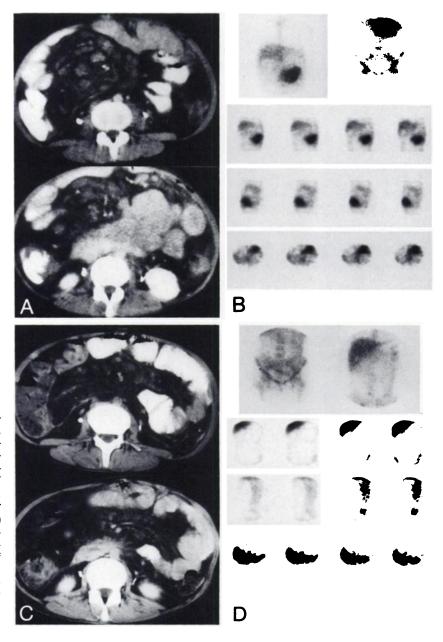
Case 1: High grade non-Hodgkin's abdominal lymphoma, diffuse immunoblastic type. (A) Midabdominal CT showing massive mesenteric and retroperitoneal lymphadenopathy. (B) Gallium-67 planar and SPECT scintigraphy in the coronal, sagittal, and transaxial planes showing anterior left paramedian abnormal uptake. (C) Midabdomen CT after treatment showing residual mesenteric lymphadenopathy. There is a complete regression of retroperitoneal nodes and residual mesenteric lymphadenopathy. (D) Gallium-67 planar and SPECT scintigraphy after therapy showing no abnormal uptake.
